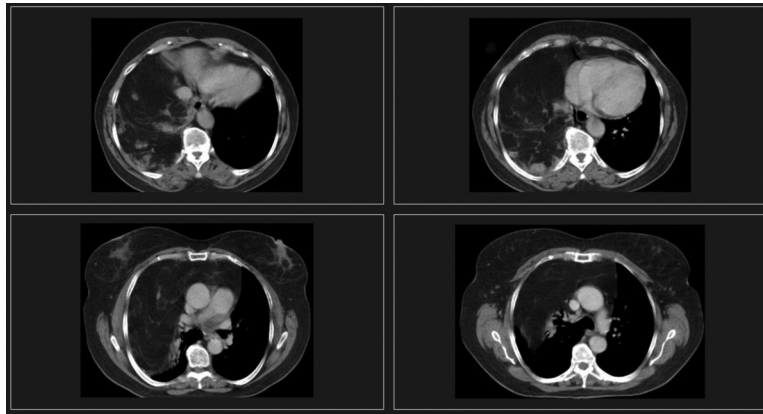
Thorax computer tomography (CT) scan, showing a huge lipomatous tumor occupying anterior mediastinum and the lower right hemithorax.
